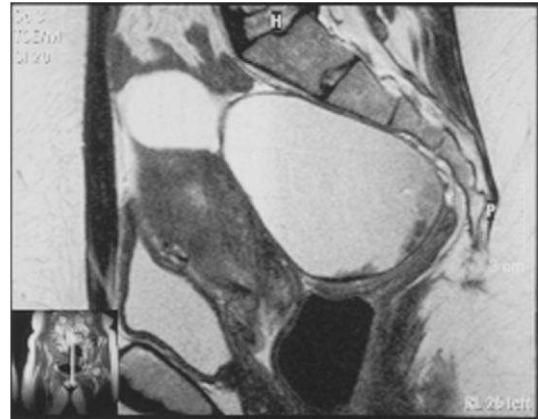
Magnetic resonance imaging with T2-weighted sequences in sagittal view.
